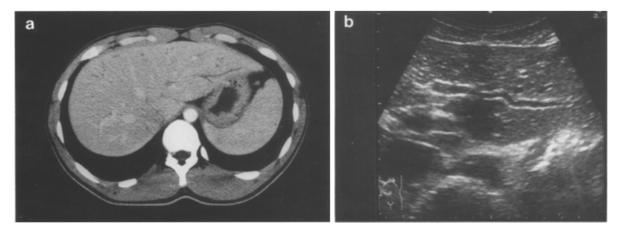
a Abdominal computed tomography scan reveals dilatation of intrahepatic bile ducts, especially in the periphery. b Ultrasonography reveals wall thickening and dilatation of intrahepatic bile ducts in the left hepatic lobe
